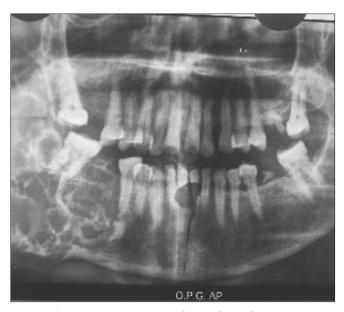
(c): Preoperative radiograph (orthopantomogram) showing large multilocular radiolucency involving condyle, coronoid, ramus, angle and body region of left mandible with expansion of lower border.
